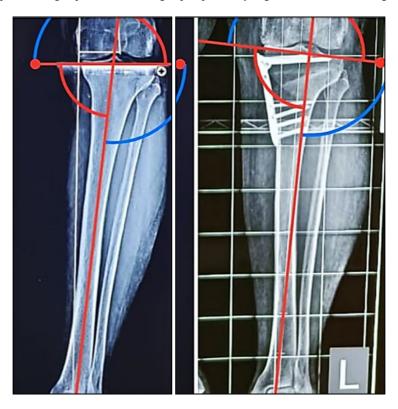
Above radiograph showing mMPTA, preoperatively angle was 83.7° which changes to 91.9°
